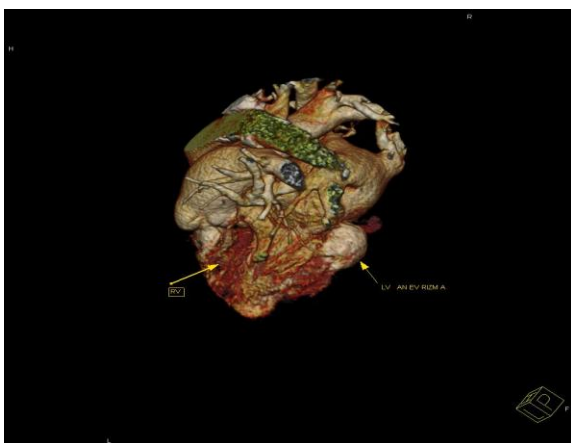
Thoracic multislice CT showed that left ventricular posterior wall aneurysm which is full of contrast and makes bulging from the lateral and posterior walls of the left ventricle.
